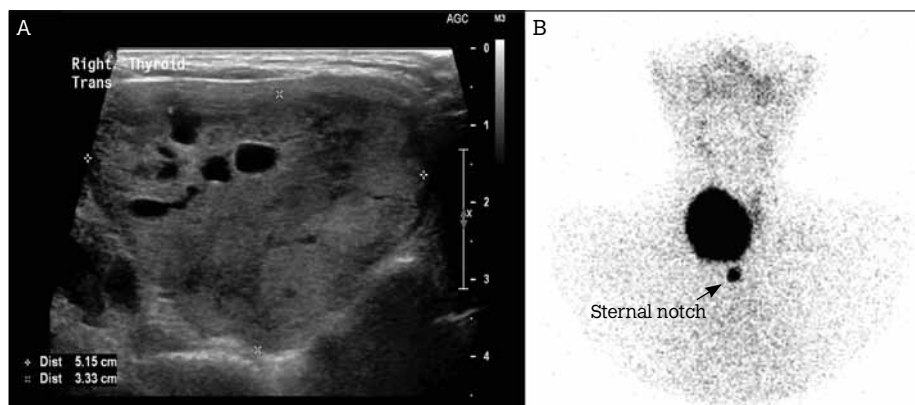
Autonomous right lobe nodule. A large nodule (measuring over 5 cm in maximum dimension) was identified on ultrasound (A). The thyroid scan (B) showed it to be hyperfunctioning
